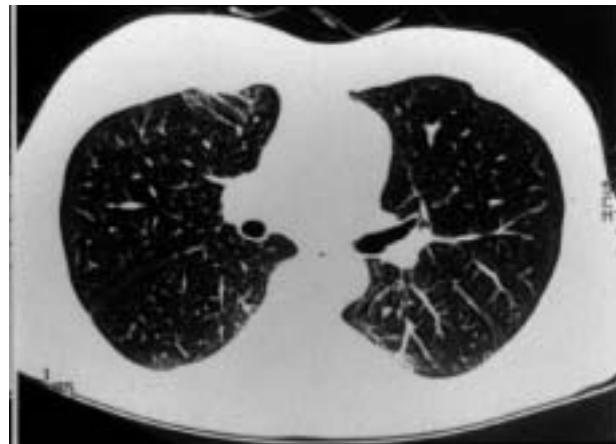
a) Computed tomography scan of the lung, showing ground-glass shadows in both lungs. b) After therapy, these shadows almost disappeared.
